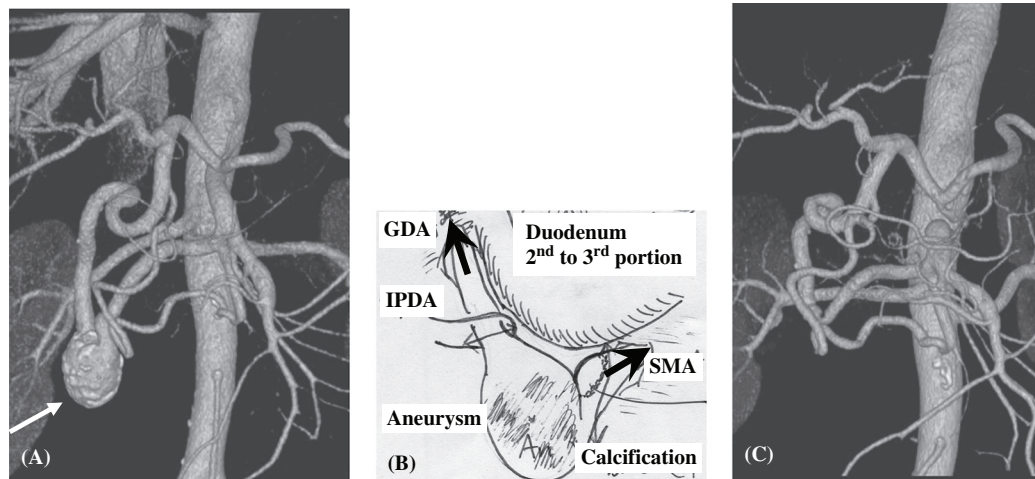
Three-dimensional computed tomography (CT) shows the inferior pancreaticoduodenal artery aneurysm (IPDAA) with calcification (A; arrow). Direct anastomosis after aneurysmectomy was performed (B). Follow-up CT shows no recurrence of aneurysm 3 years after the surgery (C) (Case 4).
